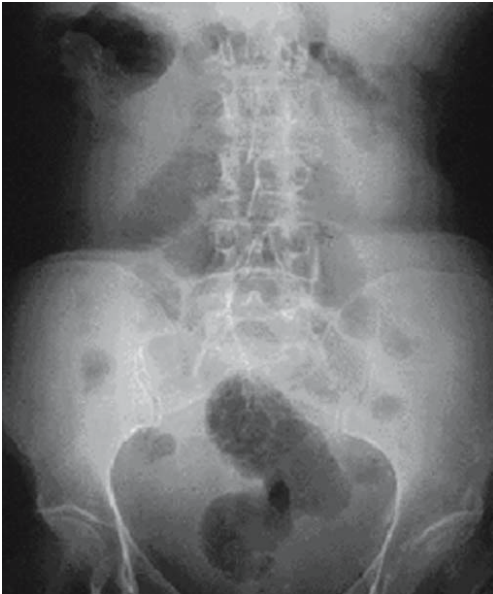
Abdominal X-ray. Massive ascites. In the supine position the bowel gas lies centrally and there is nothing peripherally. The lighter bowel loops are practically floating on a lake of ascites in the abdominal cavity
